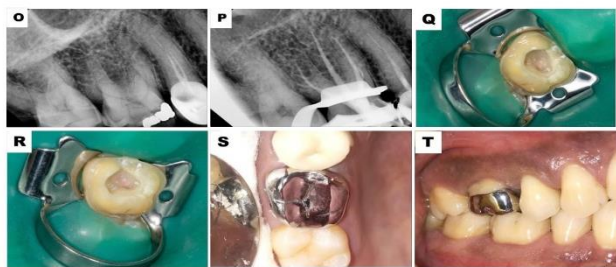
(O) PREOPERATIVE RADIOGRAPH (P) OBTURATION RADIOGRAPH (Q) ACCESS CAVITY REFINED (R) ENDOCROWN PREPARATION (S&T) ENDOCROWN LUTED PHOTOGRAPH
